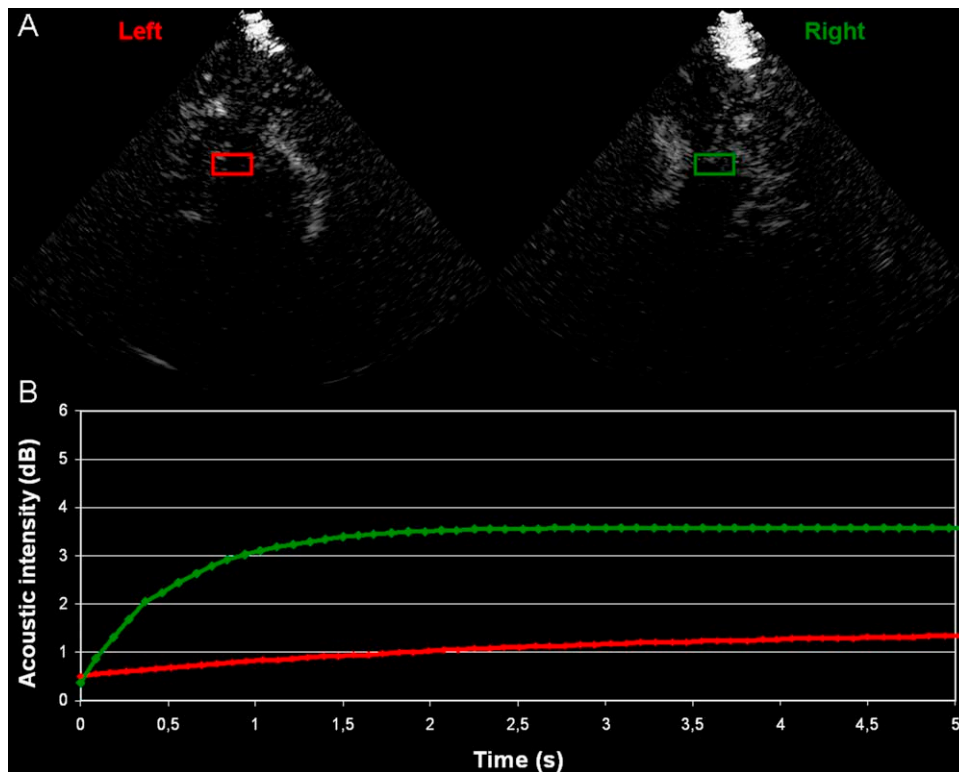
Real time ultrasound perfusion imaging (rt-UPI) of both hemispheres (A) with corresponding regions of interest in the ischemic area of the left (red) and the contralateral MCA territory (green). Refill kinetics (B) show a flattened curve with low slope of the exponential function in ischemic tissue (red), and a normal replenishment of microbubbles in the contralateral hemisphere (green).
